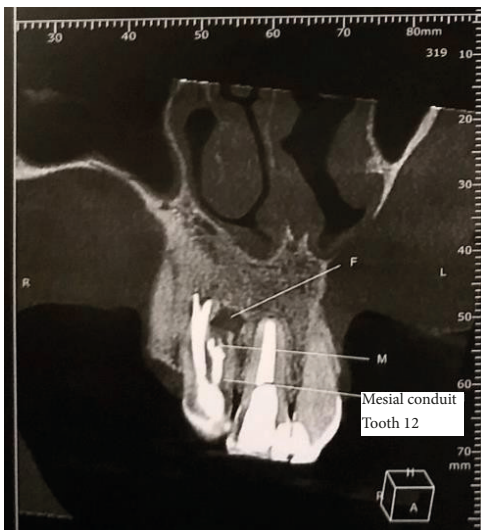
Coronal volumetric computed tomography image showing the periapical lesion in the mesial root and the perforation with leakage of filling material in the distal root.
